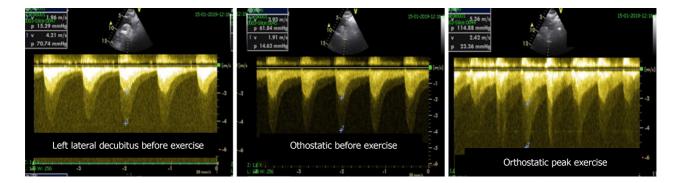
Aortic gradient evaluated in a patient previously treated with a stent. Based on the exercise stress echocardiography results, the patient was treated again.
